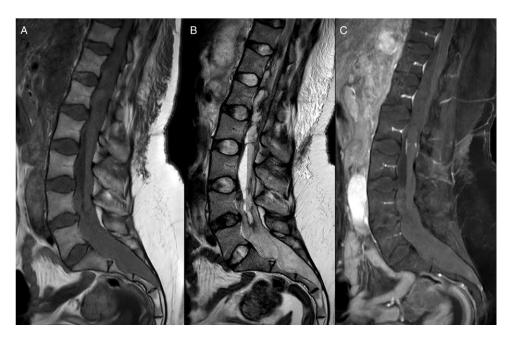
The lumbar MRI was performed with T1w (a), T2w (b), and post-contrast T1w with fat saturation (c) sequences. The dural sac is filled with inhomogeneous content due to different phases of hemoglobin catabolism. A collection with a fluid level is evident posteriorly to L2–L3, with focal contrast enhancement related to active bleeding ("spot-sign"). Dural ectasia, according to the Ghent nosology, represents a major diagnostic criterion of Marfan syndrome; it is defined as a dilatation of the dural sac (and the subsequent expansion of the spinal canal), and is very evident in this patient.
